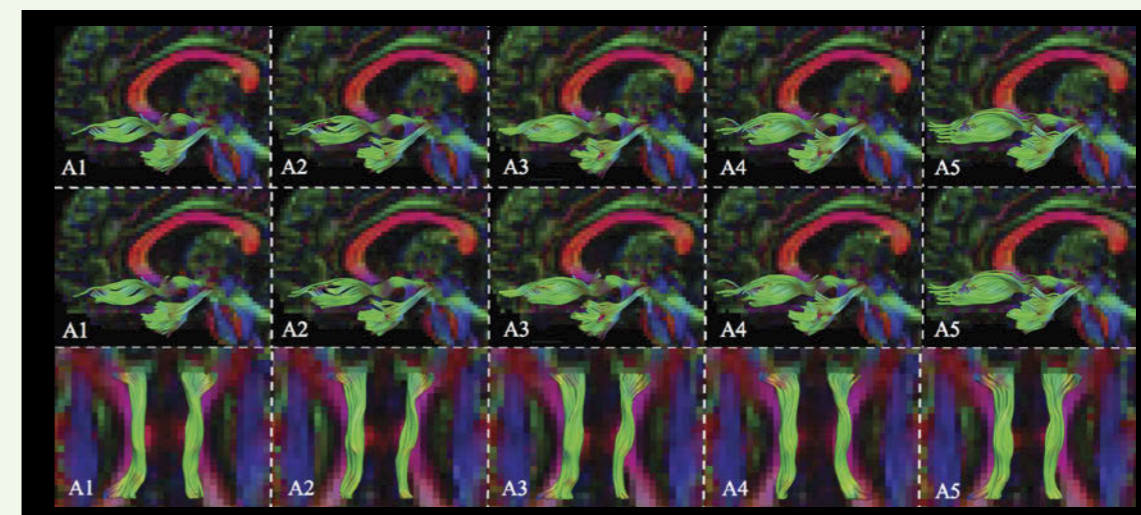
Automated extraction of the forceps minor (top row), uncinate fasciculus (middle row) and body of the cingulum bundle (bottom row) using Automated longitudinal intra-subject analysis (ALISA) for diffusion MRI tractography for one subject at 5 time points.
